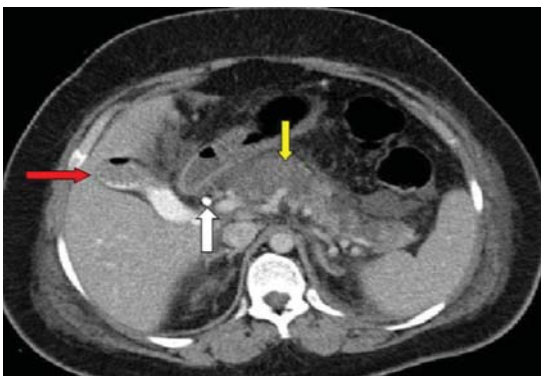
CT scan before intervention with infected pancreatic necrosis (yellow arrow) after biliary stent placement (white arrow). Red arrow shows multiple gallstones and air in lumen of gallbladder.
